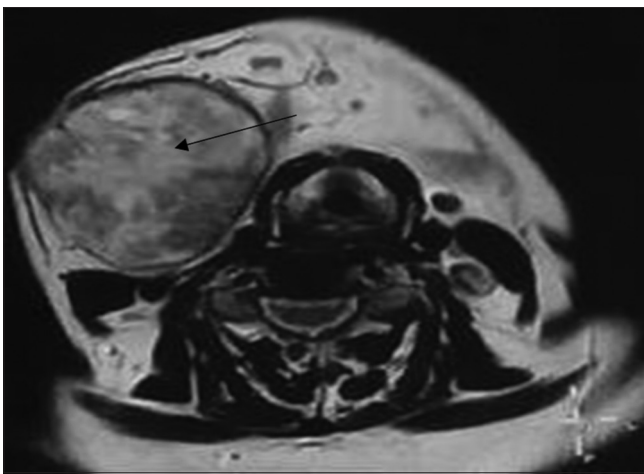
Magnetic resonance imaging of face and neck showed well defined globular swelling in the right side of neck measuring 13 x 10 cm, with well-defined capsule, compressing the carotid sheath with no definitive infiltration
